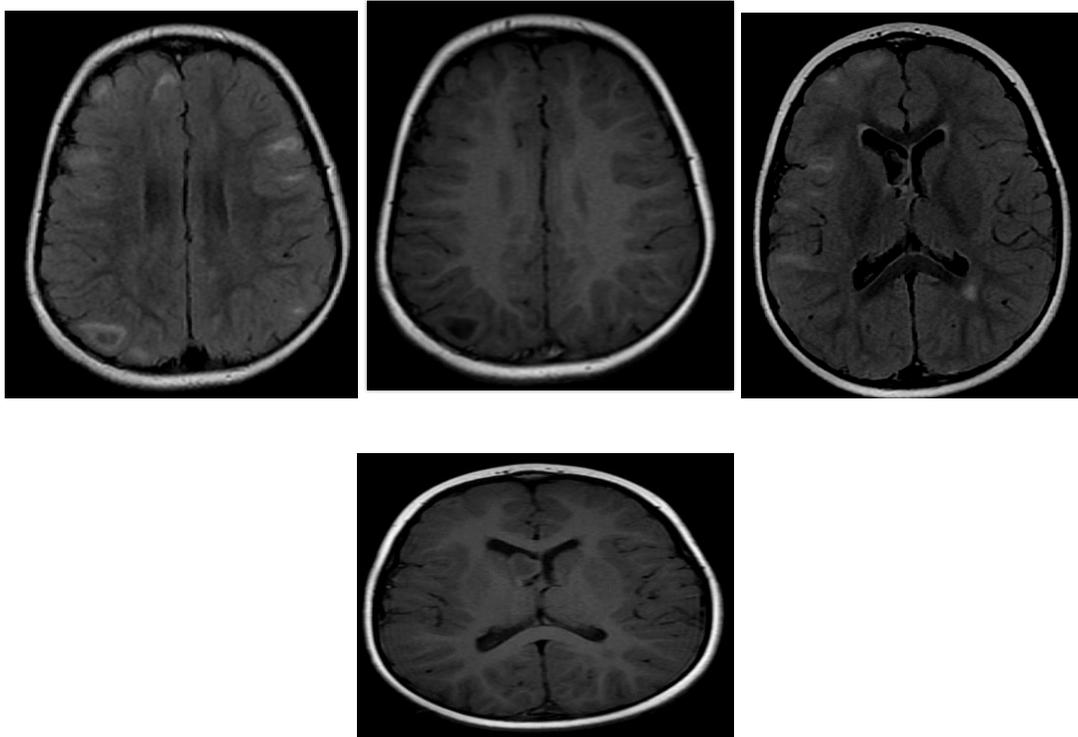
Cortical/subcortical areas of hypersignal in T2 FLAIR (A and C), the largest ones showing low signal correspondence in T1 (B and D) in the cerebral hemispheres, without enhancement after contrast medium injection, without restriction to molecules of water, usually related to cortical tubercles, in a 2-year-old male patient.
